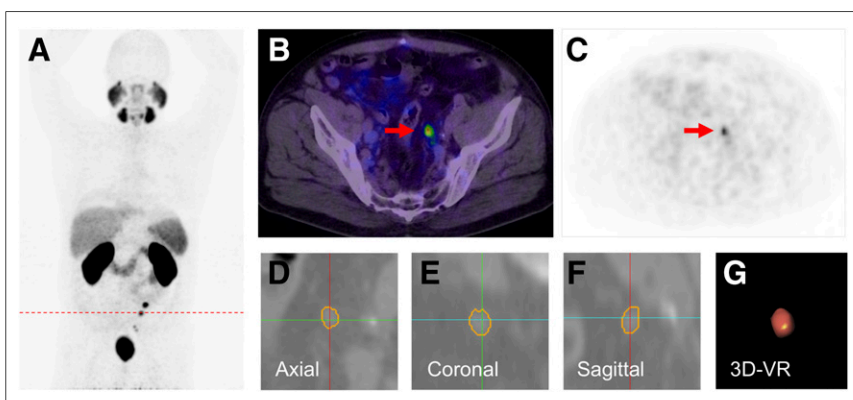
A 58-y-old patient with PSA relapse of 4.9 ng/mL, 9 mo after prostatectomy (GS, 6; iPSA, 10 ng/mL). (A) Patient presented multiple ^{68}Ga -PSMA PET-positive nodes as shown in PET maximum-intensity projection. (B and C) A positive node (red arrow) with PSMA uptake SUV_{max} 7.2 was segmented using Fraunhofer MEVIS software (SAD, 5.93 mm; LAD, 7.73 mm; and volume, 0.31 mL) Images (D–F) show segmented lymph node on each plane and volume rendering (VR) (G).
